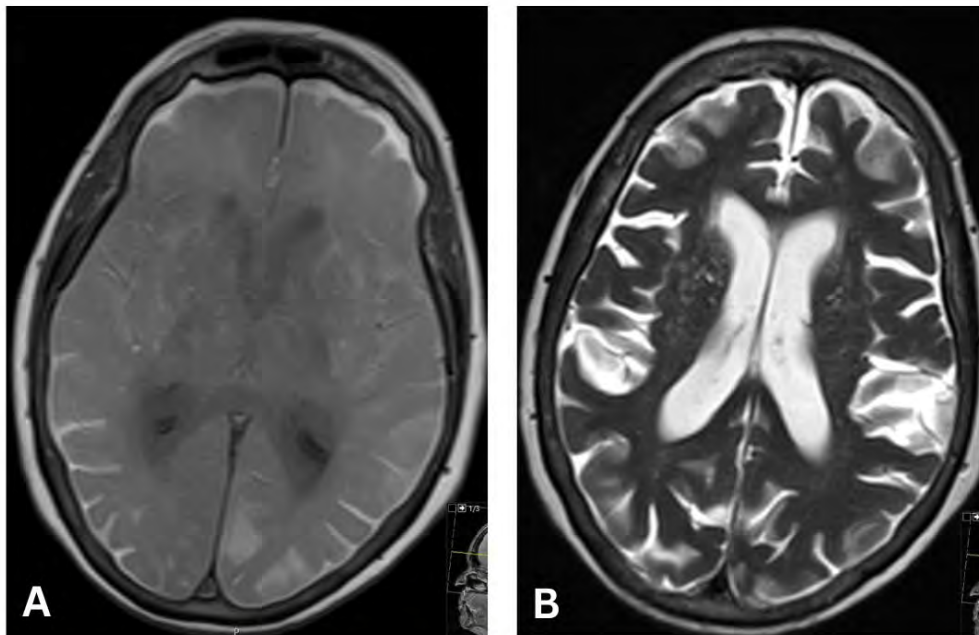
Case of a 86-year-old female who presented after the development of generalized seizures following a cervical epidural steroid injection. A) Axial pre-contrast T1-weighted and B) Axial T2 FLAIR images demonstrate extensive T1 hyperintensity diffusely throughout the extra-axial spaces along both cerebral convexities.
